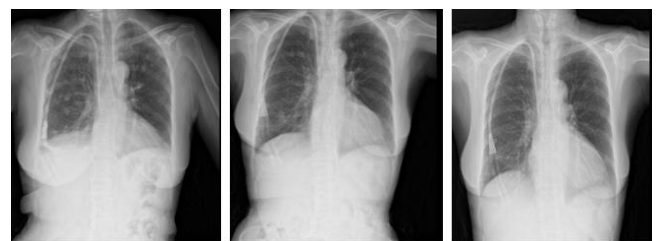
Almost complete regression noted on posteroanterior radiographs after antibiotic treatment
